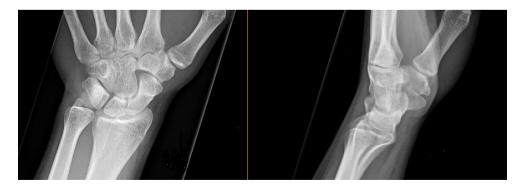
Radiographs of the contralateral uninjured side of the same patient for comparison
